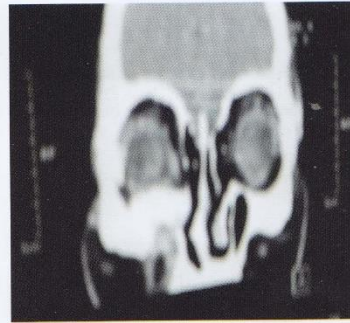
Post- operative CT Scan in Coronal view of Iliac bone graft in right orbital floor
